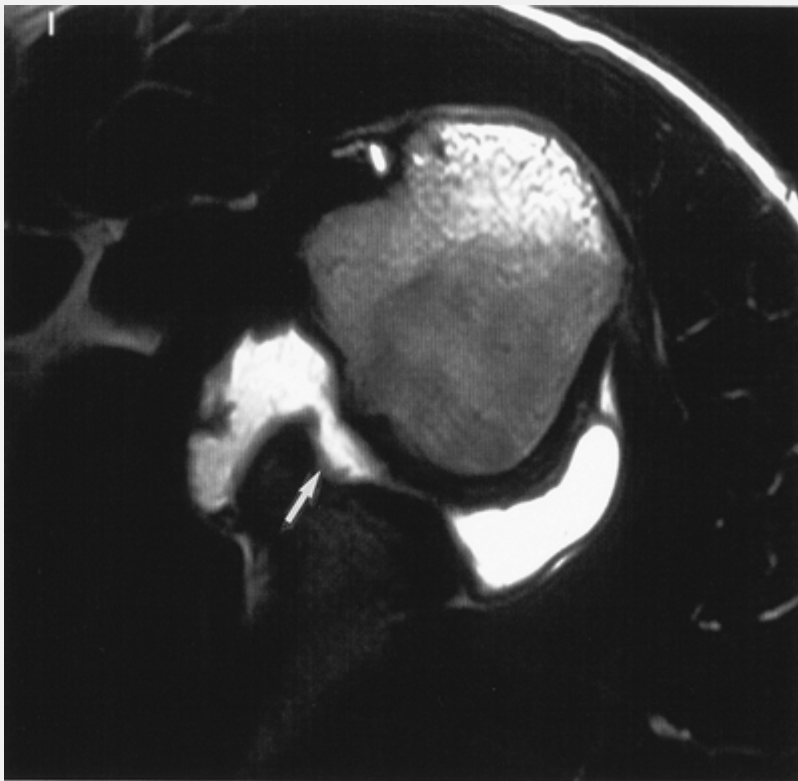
MRI of SLAP lesion. A coronal oblique T2\*-weighted MRI shows a type II SLAP lesion involving anterior superior glenoid labrum (L). Note linear high intensity signal extending across the base of the labrum (arrow).
